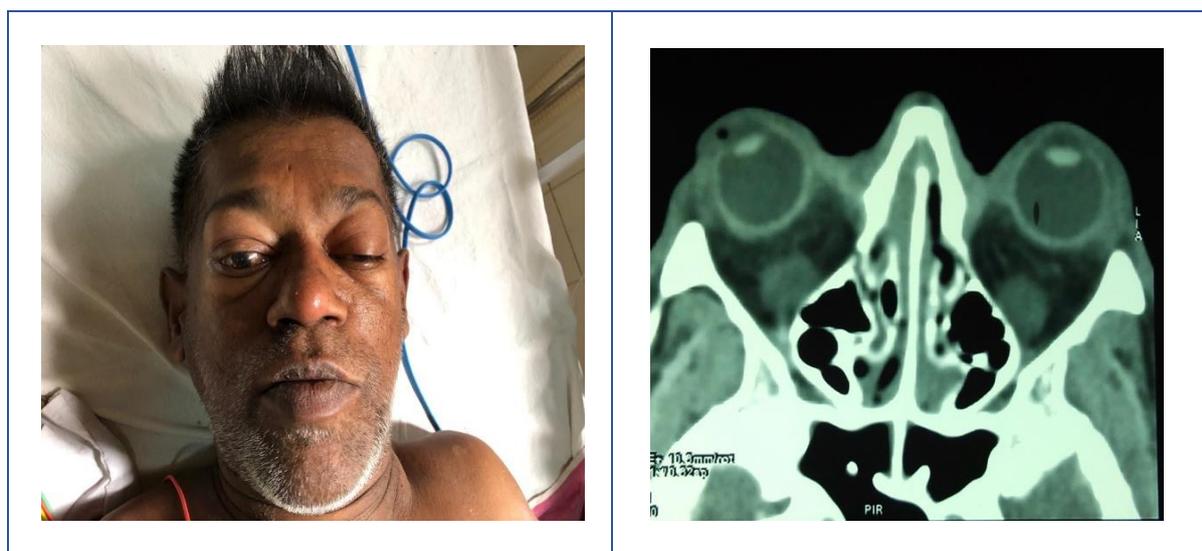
Acute presentation with bilateral proptosis and left sided partial ptosis and MRI revealing bilateral proptosis
